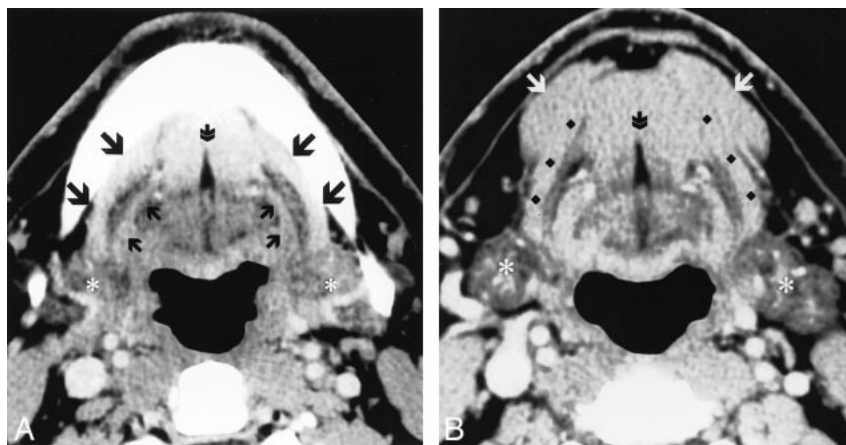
Normal postcontrast axial CT images through the oral cavity. *B* is caudal to image *A*. The classic anatomy of the mylohyoid muscle (*A*, large black arrows; *B*, black diamonds) is seen forming a continuous muscular barrier separating the deep sublingual space from the superficial SMS. Running parallel to the posterior aspect of the mylohyoid muscle is the hyoglossus muscle (small black arrows). On either side of the fibro-fatty lingual septum (double arrow) are the genioglossus muscles cranially, and the geniohyoid muscles caudally. Caudally, the anterior belly of the digastric muscle (white arrows) blends with the superficial margin of the mylohyoid muscle. Asterisks signify the submandibular glands (18).
